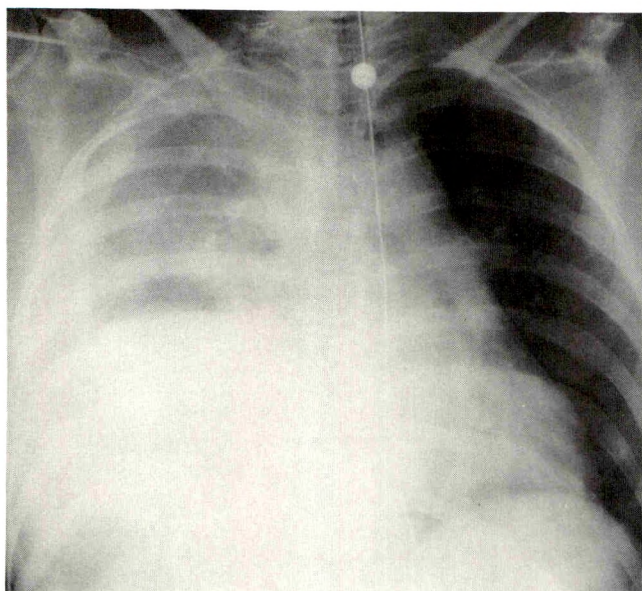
Chest radiograph shows elevated right hemidiaphragm, shift of mediastinum and nasogastric tube to left, and right-sided pleural effusion. Surgery revealed right diaphragmatic tear with herniation of liver into right hemithorax.
